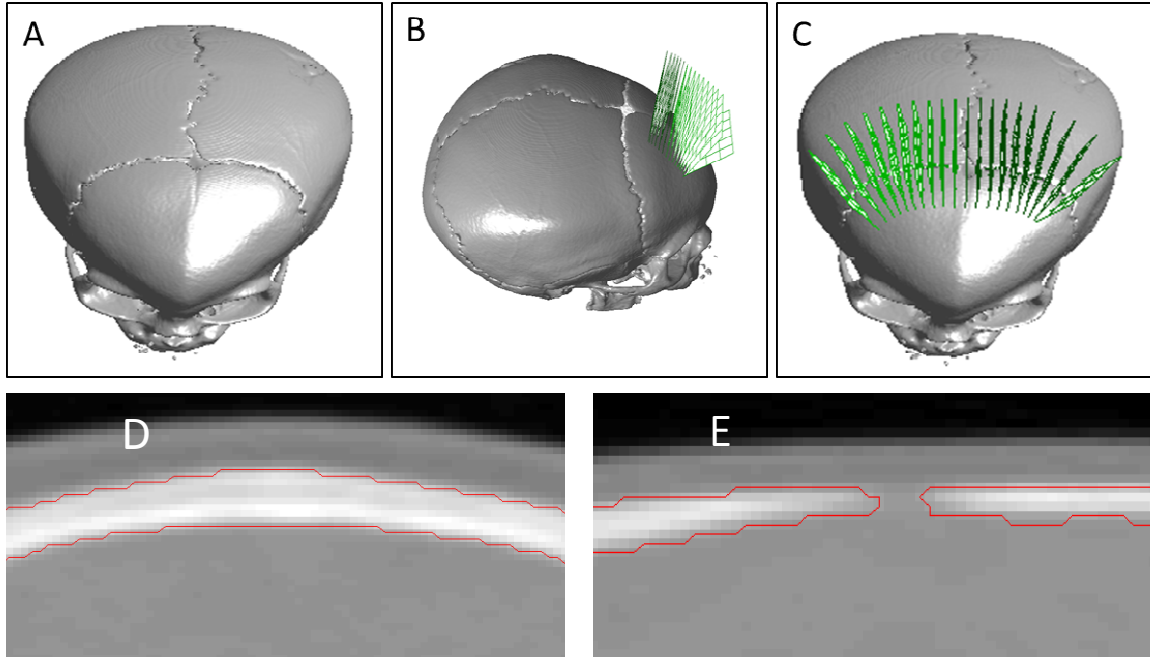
3D Reconstructions of Human Craniosynostosis CT Scans. 3D rendering of 6 month of male with non-syndromic metopic synostosis. The algorithm was used to reconstruct images (green planes) of the pathologically fused metopic sutures (b) and open coronal suture (c). Segmentation boundaries (red line) following reconstruction and segmentation of representative images from fused metopic (d) and open coronal (e) sutures.
